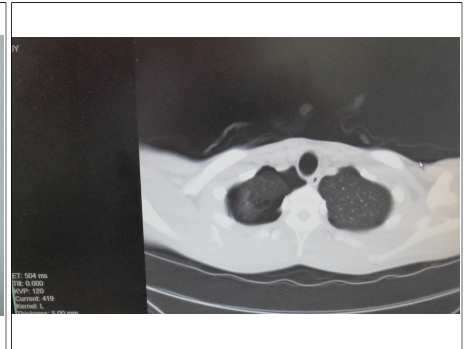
Preoperative chest CT images.
